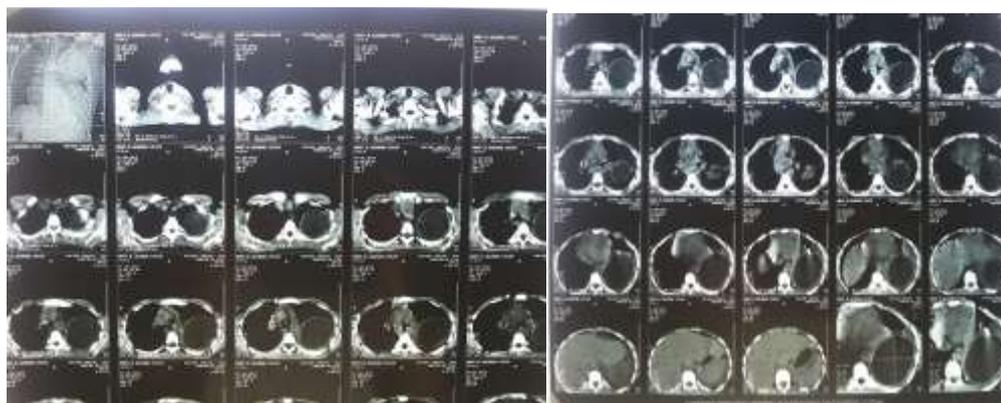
CT thorax showing fluid containing cystic lesions in left upper & lower lobes
